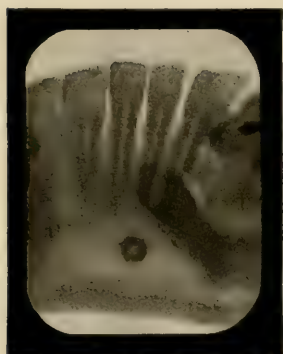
Radiograph of the lingual tubercle.
